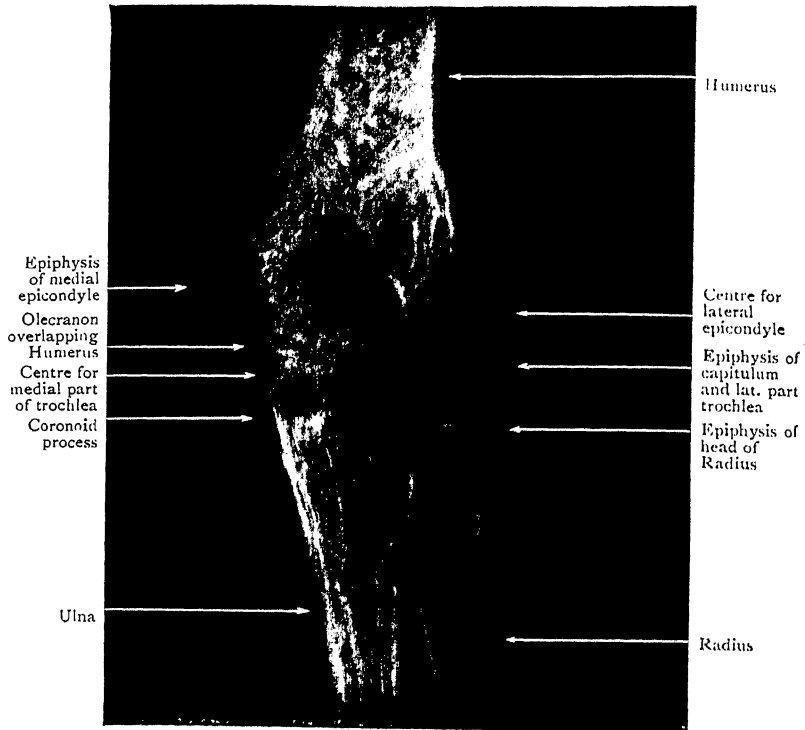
Radiograph of Elbow of boy aged 12, showing all epiphysal centres. The three centres for (1) capitulum and lateral part of trochlea, (2) medial part of trochlea, and (3) lateral epicondyle, unite to form a single epiphysis. Note the olecranon epiphysis above the part of the olecranon that overlaps the Humerus. Cf. Figs. 86 and 87 for earlier and later stages of development of epiphyses.
